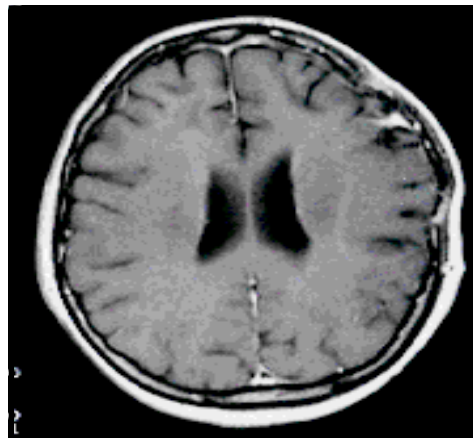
Follow-up axial brain magnetic resonance image 6 months later showing complete resolution of the 2 lesions.
